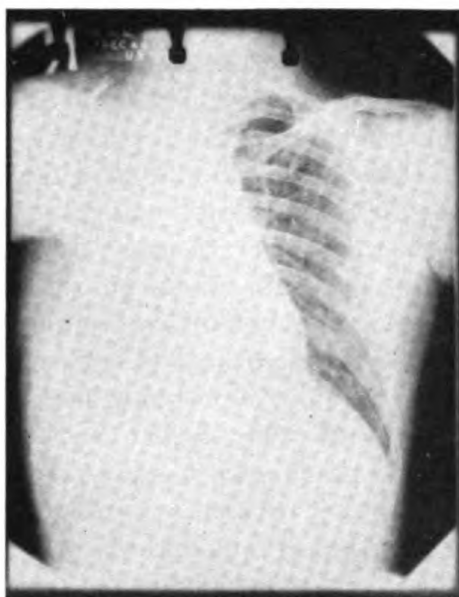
Roentgenogram taken following resection of right lung and five rib thoracoplasty. Left lung fields clear. Gastric culture negative for acid-fast bacillus.
